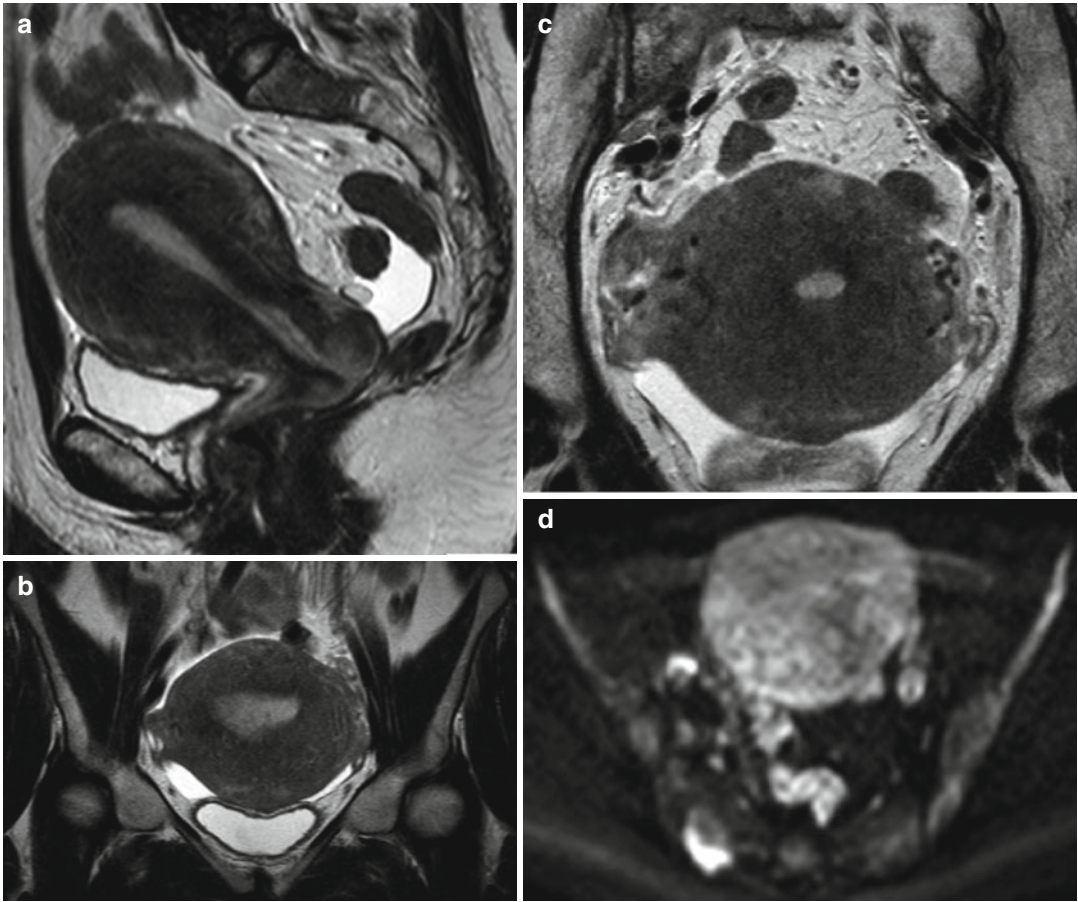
Metachronous uterine metastasis in a 40-year-old woman with history of invasive ductal breast carcinoma: T2-weighted sagittal (a), coronal (b), and transverse small field of view (c) images demonstrate an enlarged
